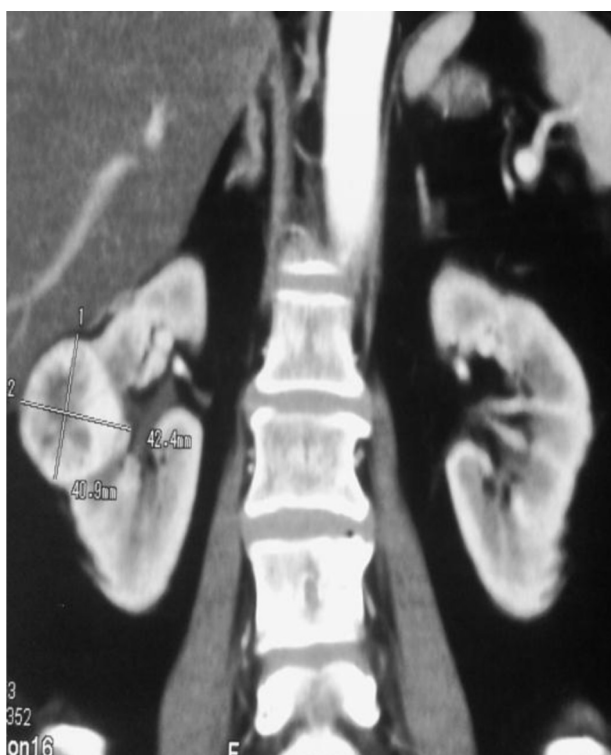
Cross section of a CT showing an anterior tumor and exophytic.
